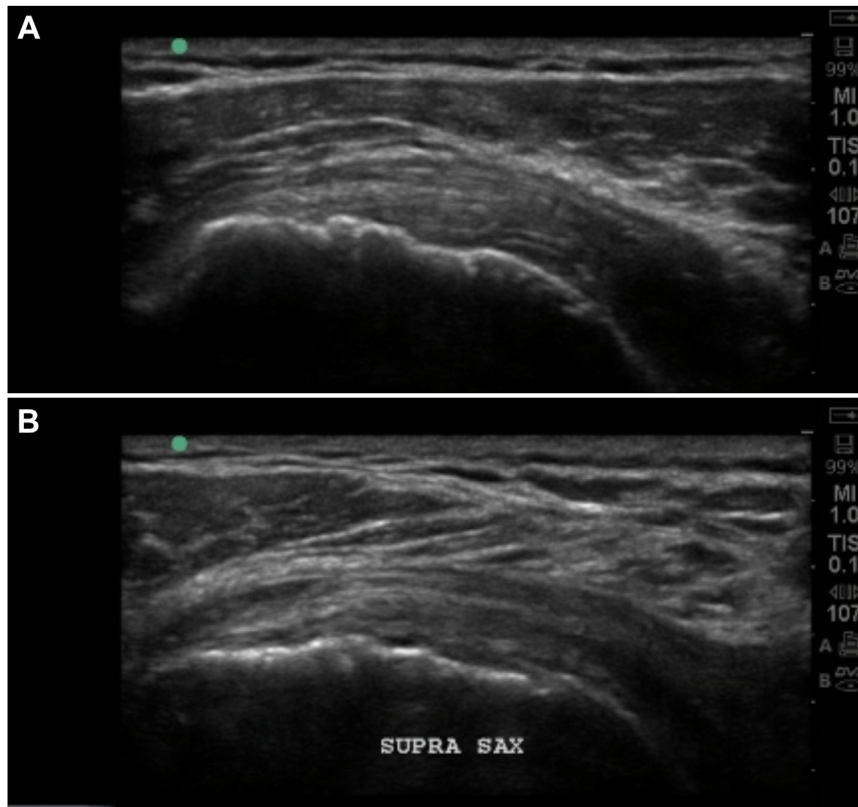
(A and B) US measurements of supraspinatus tendon demonstrated thickening from Case 13. (A) supraspinatus long-axis. (B) supraspinatus short-axis. US, ultrasound.
